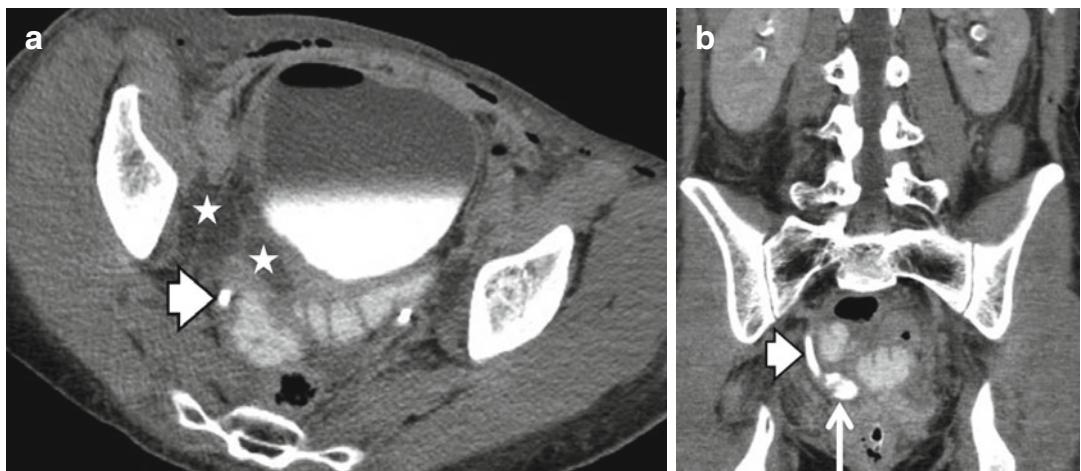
Ureteral injury after radical hysterectomy. Transaxial (a) and coronal (b) CT urography scans 5 days after surgery show loculated pelvic fluid collections (*)
